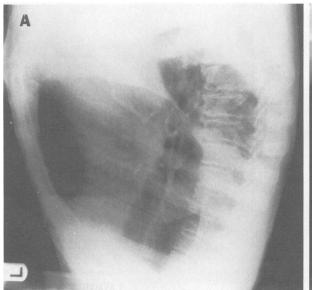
Initial chest roentgenograms showing a left pleural effusion. A, posterior anterior view, B, lateral view.
